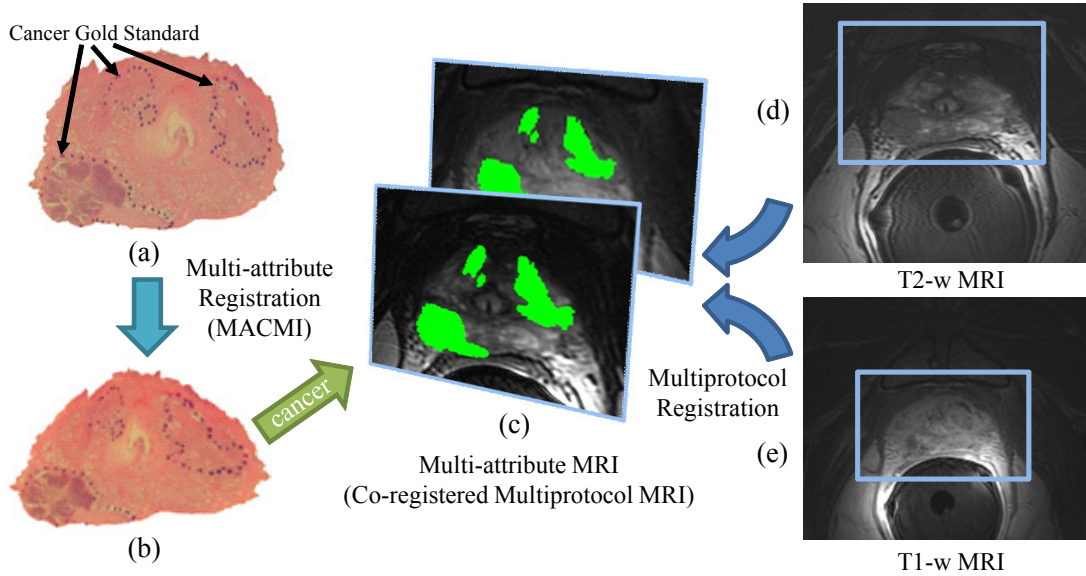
Establishing disease signatures on *in vivo* multiprotocol MRI using MACMI for registration of (a) WMH sections to corresponding (d) T2-w and (e) T1-w MRI. Alignment of the T2-w and T1-w MRI allows generation of (c) the multi-attribute MRI comprised of co-registered multiprotocol MRI. MACMI is used to align (a) WMH to (c) the multi-attribute MRI. CaP extent on the (b) elastically registered WMH is mapped directly onto both MR images in (c).
